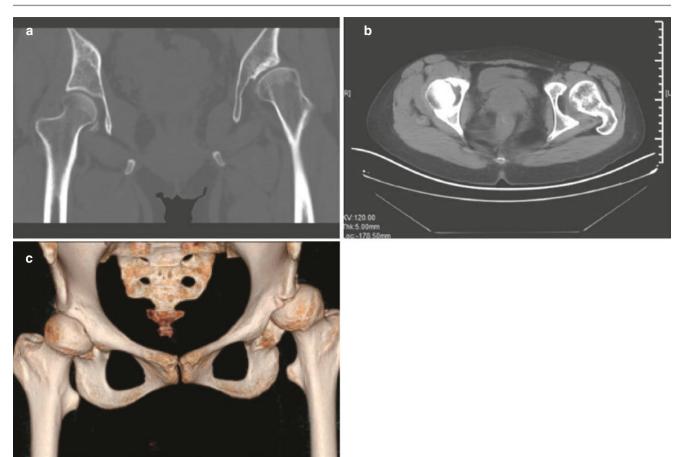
Pelvic CT scanning. Left DDH. (a) Coronal plane; (b) horizontal plane; (c) three-dimensional reconstruction
